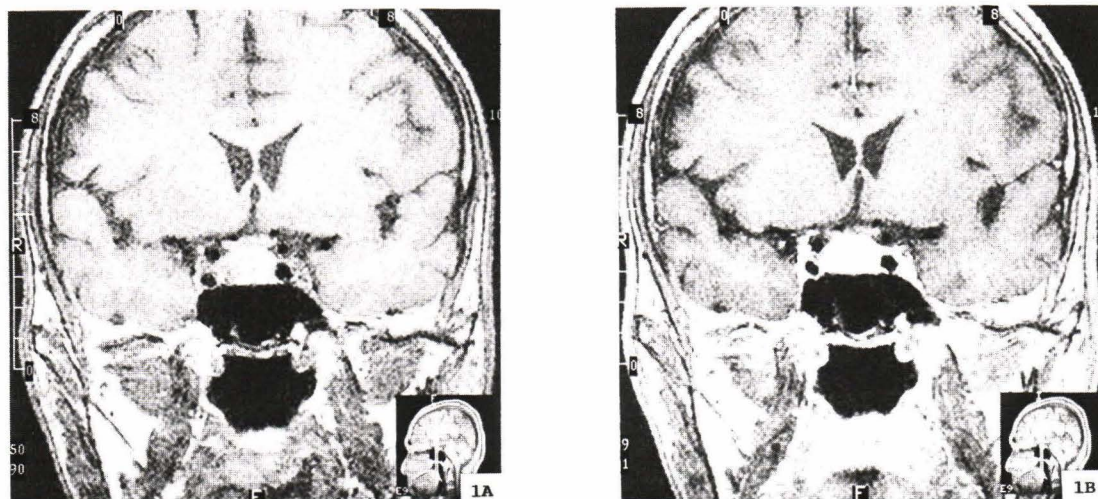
MRI of pituitary and hypothalamus without contrast agent (1A) and with contrast agent (1B) demonstrates intrapituitary mass size approximately 20 x 13 mm with heterogeneous enhancement after contrast agent injection. The floor slants and superior convexity is noted. Right lateral displacement of carotid vessel is noted as well as visualized superior displacement of optic chiasma. There is no hydrocephalus.
